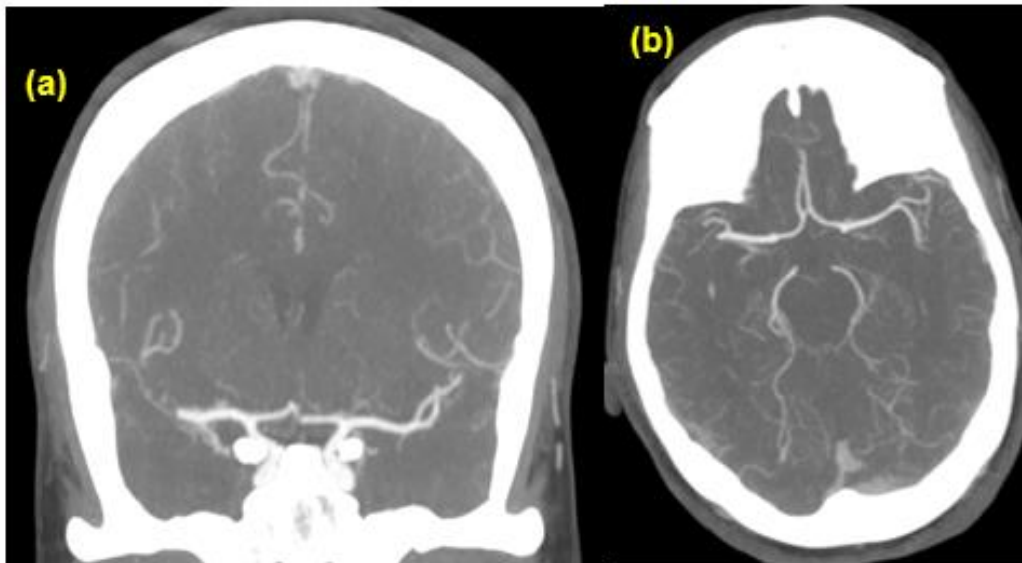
CT angiography demonstrating distal M1 segment occlusion of the right middle cerebral artery (yellow arrow): (a) coronal view and (b) axial view
